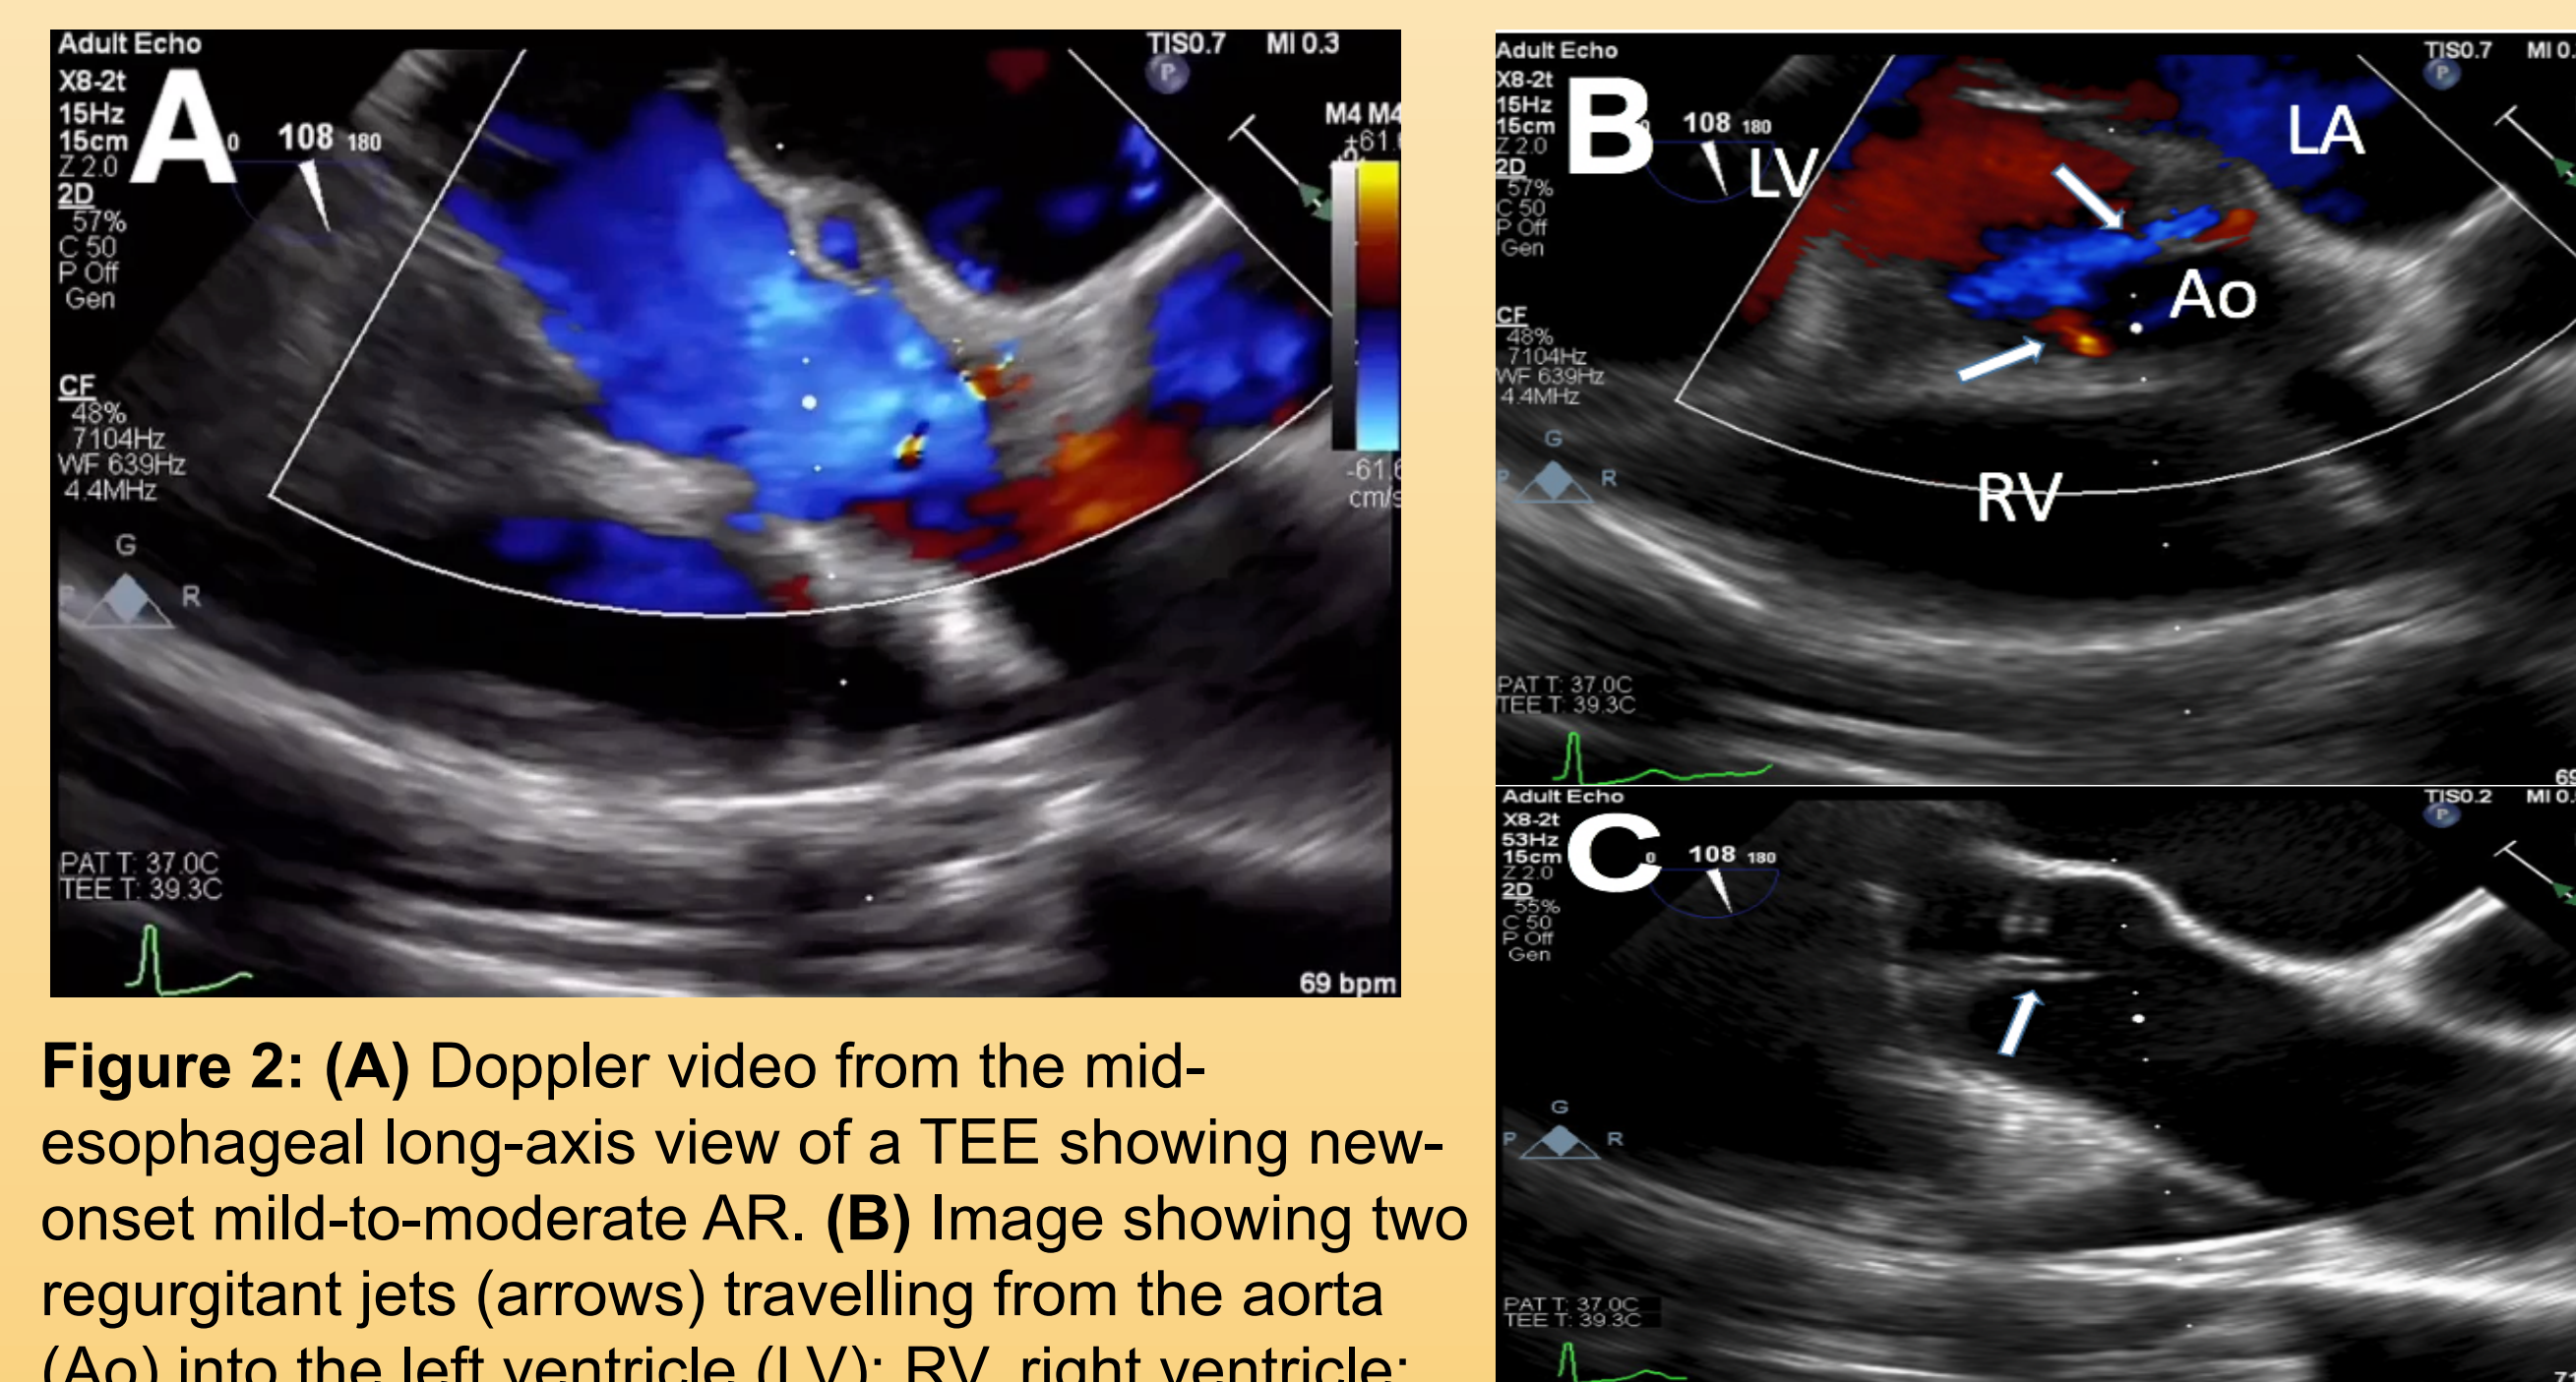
(A) Doppler video from the mid-esophageal long-axis view of a TEE showing new-onset mild-to-moderate AR. (B) Image showing two regurgitant jets (arrows) travelling from the aorta (Ao) into the left ventricle (LV); RV, right ventricle; LA, left atrium. (C) Structurally normal aortic valve (arrow) from the same view in standard ultrasound mode.
